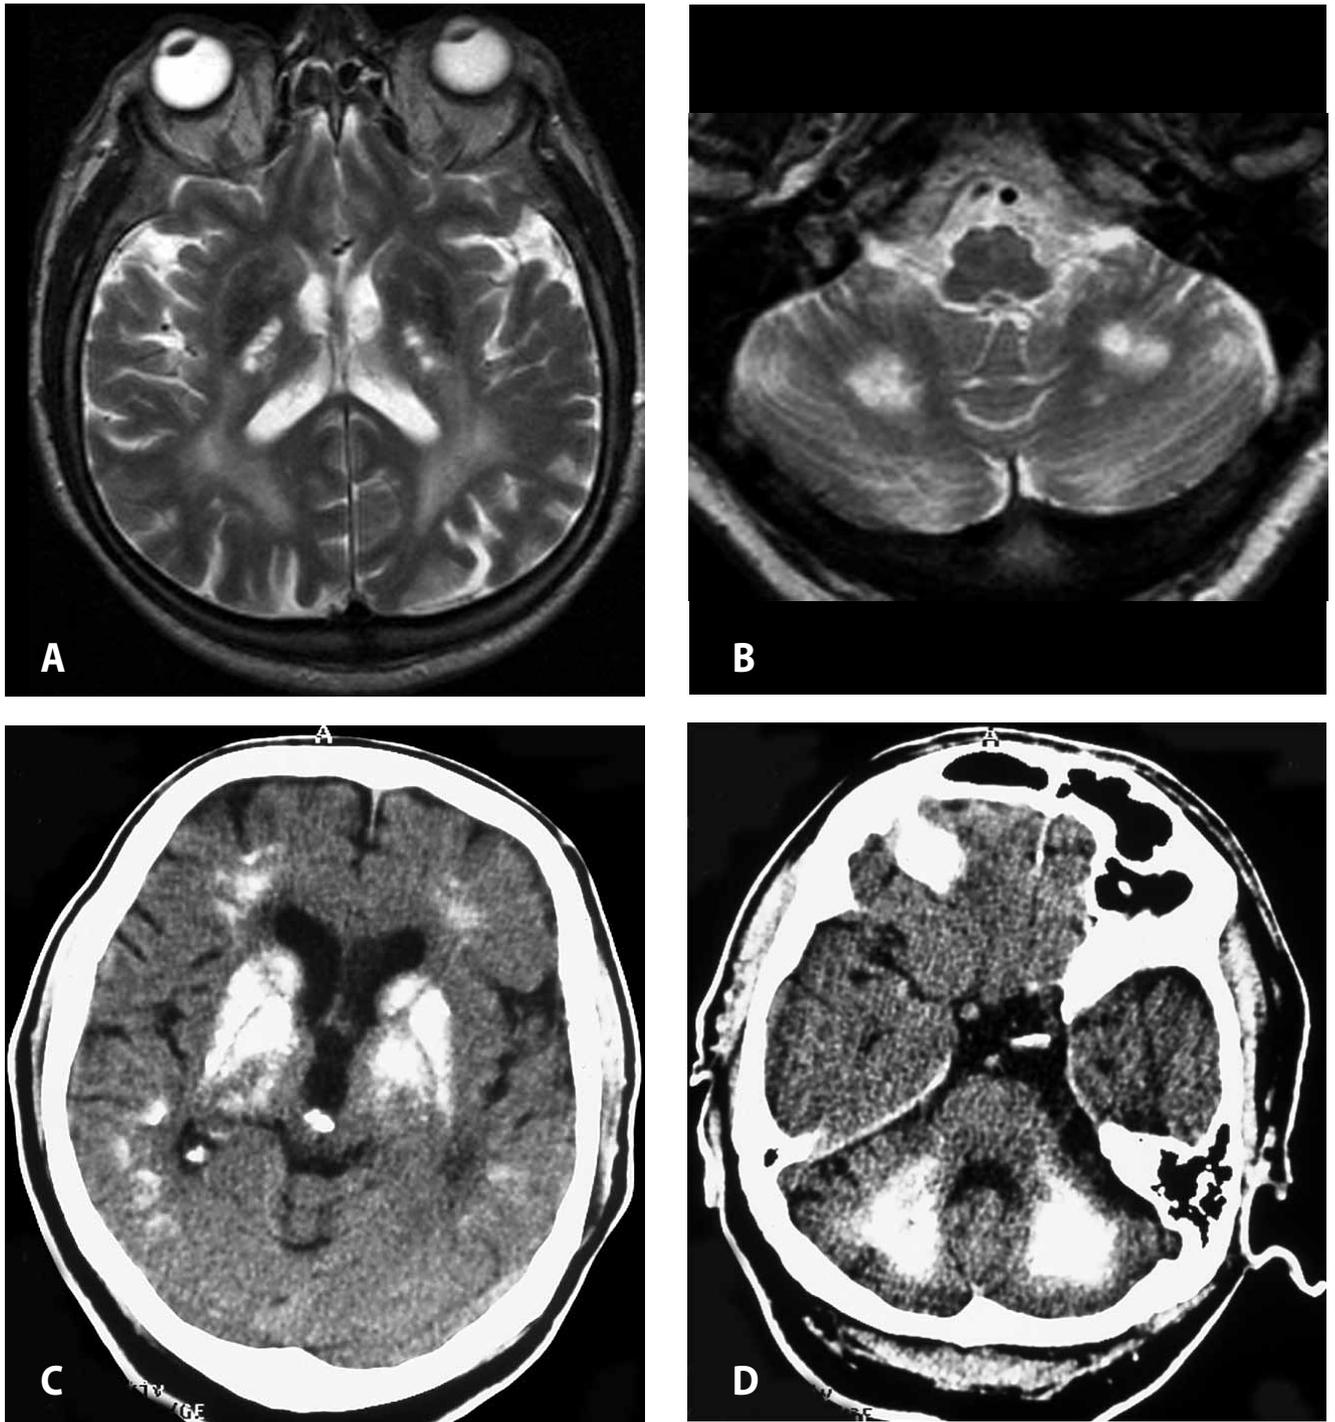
Symmetric T2W hyperintense lesions in posterior crus of internal capsule (A) and cerebellum (B) in a 64-year-old male patient with Fahr disease presented with dysarthria and ataxia associated with much more extensive areas of calcifications on corresponding CT images (C and D). Underlying abnormalities on MR images appear to be responsible for neurological symptoms.
